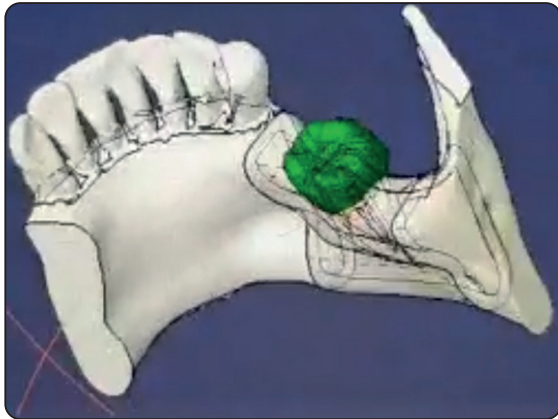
Alignment of the model tooth in produced STP file of a human mandible from CBCT library representing cancellous bone covered with the cortical bone.
